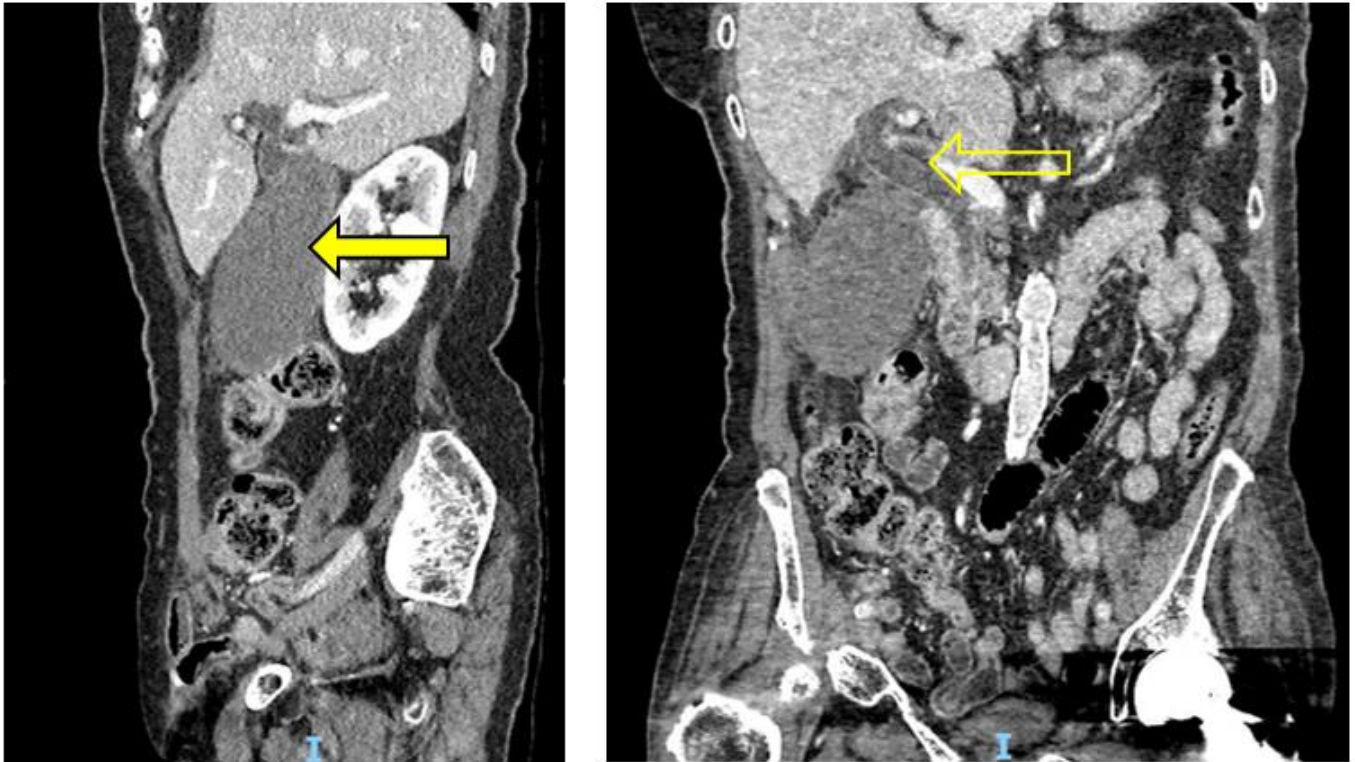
CT scan demonstrating grossly enlarged gallbladder (filled arrow) with common bile duct dilation (open arrow) in sagittal and coronal planes.
